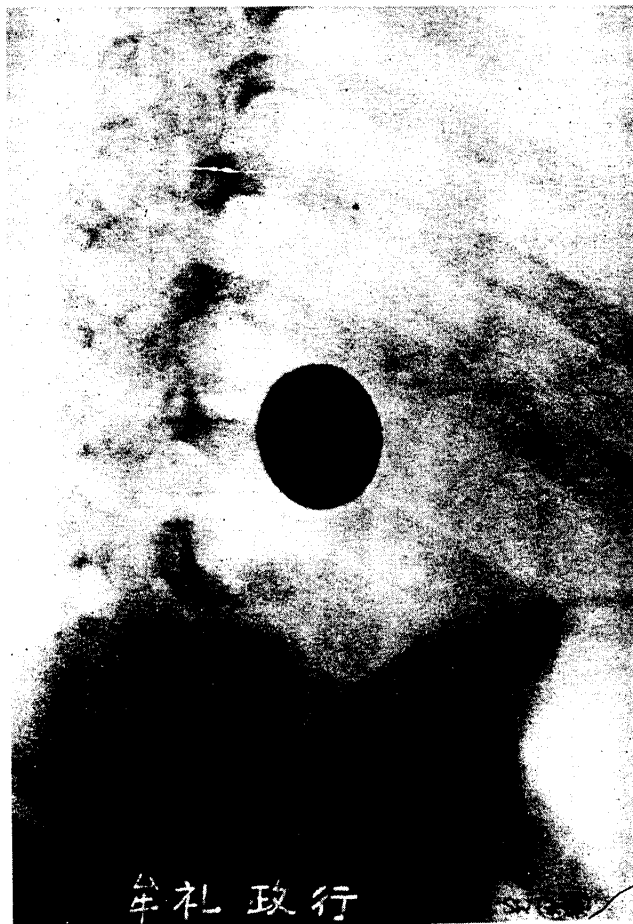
Roentgenogram of Case 2, an 8-year old boy.
